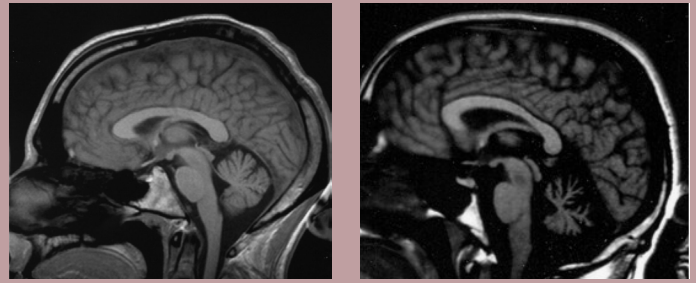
MRI showing a healthy cerebellum (left) and one experiencing degeneration from ataxia (right).
